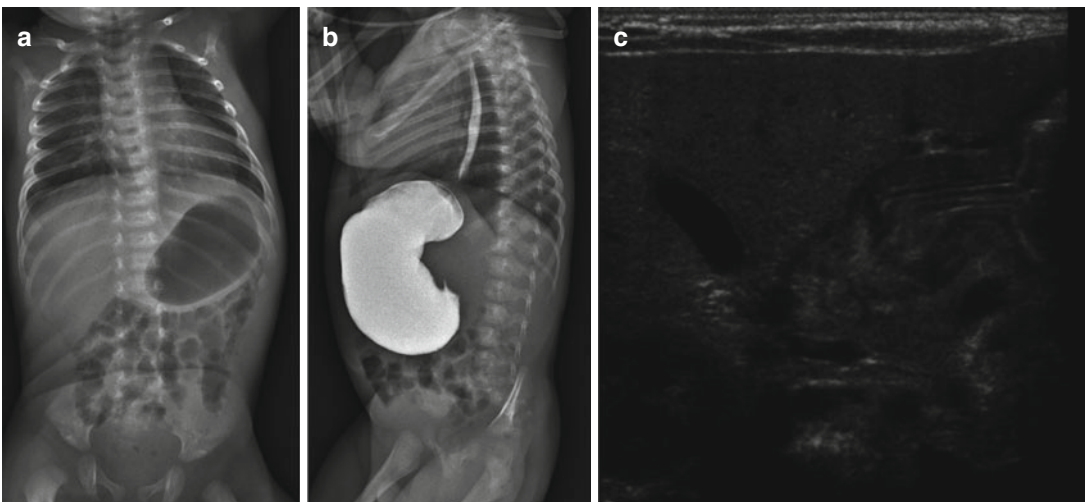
Newborn with HPS. (a) Plain film, (b) UGI tract and (c) ultrasound images show, respectively, nonspecific and specific signs of HPS
